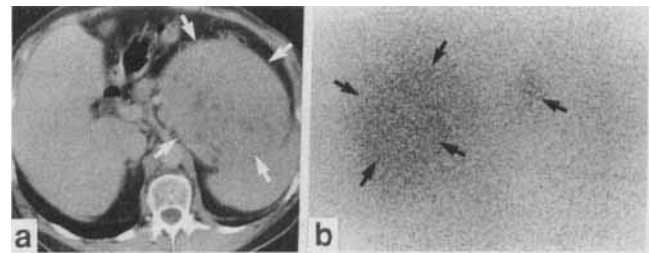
a Abdominal computed tomography scan depicts a large left-sided retroperitoneal mass (arrows) and enlarged periaortic lymph nodes. b Posterior ¹³¹I-6-β-iodomethyl-19-norcholesterol scan demonstrates radiotracer uptake in the mass (arrows) and in the normal right adrenal gland (arrow)
